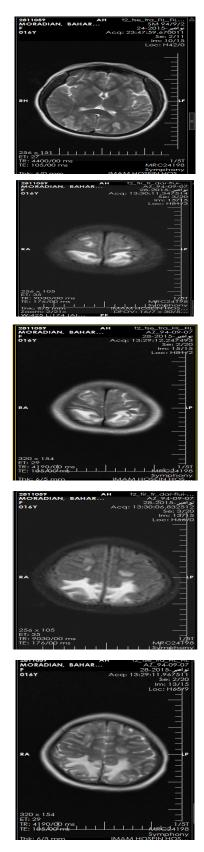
Cerebral magnetic resonance (FLAIR) imaging in a patient with PRES. It shows bilateral hyper-intense signal predominantly in occipital and frontal lobes
